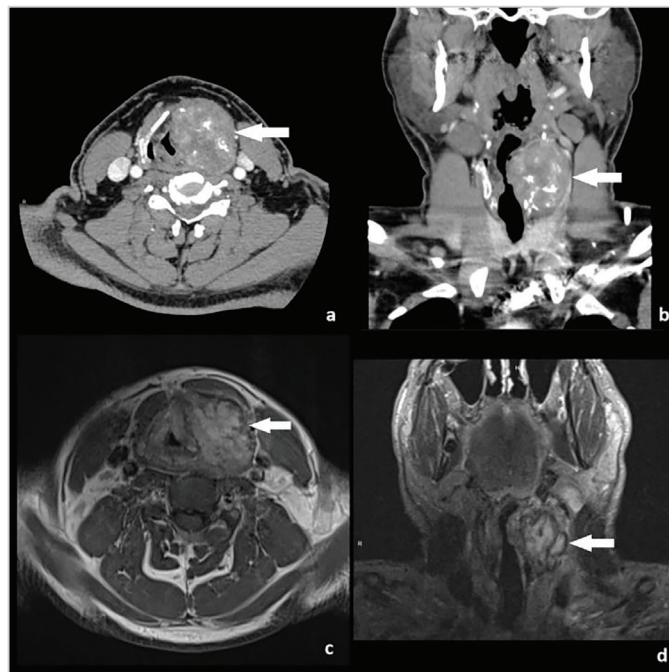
a, b) Axial and coronal computed tomography sections of the neck demonstrate a mass in the left side with cystic-necrotic components and calcifications, completely destroying the thyroid cartilage and extending to the left false and true vocal cords, resulting in airway obstruction. c, d) Axial T1-weighted and coronal T2-weighted magnetic resonance imaging show a heterogeneous mass in the same region (Arrows indicate the mass.)
